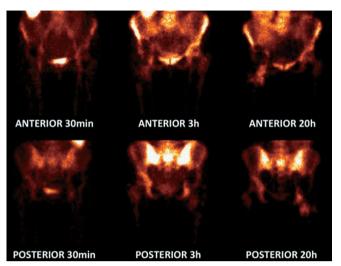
A case of suspected PJI studied with <sup>99m</sup>Tc-HMPAO-WBC. Images were acquired in antero-posterior at 30 min, 3 h and 20 h with acquisition time corrected for isotope decay and displayed in absolute counts. The presence of osteomyelitis with soft tissue involvement is clearly defined in 20 h images without the need of SPECT/CT. Hybrid images, however, can add useful information on the extent of the infection.
